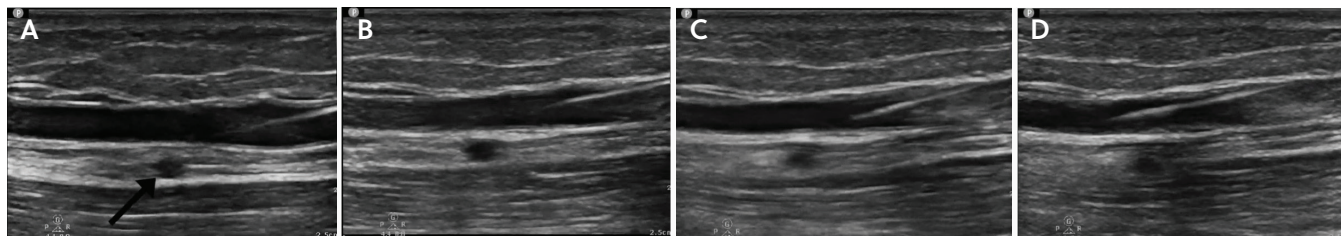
Ultrasound images of the ClosureFast 6-Fr catheter navigating a vein bend without a guidewire. Catheter enters the mid-thigh perforator (A); catheter pulled back into the GSV (B); gentle torque applied (C); advanced cephalad into the GSV (D).
